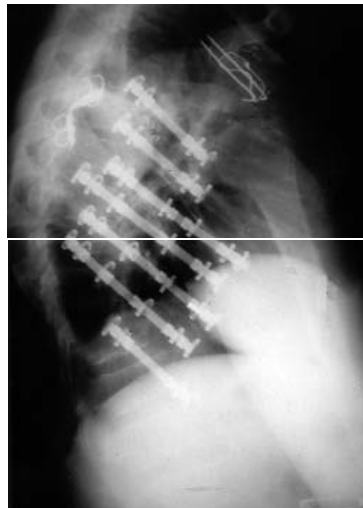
Post-operative profile X-ray
